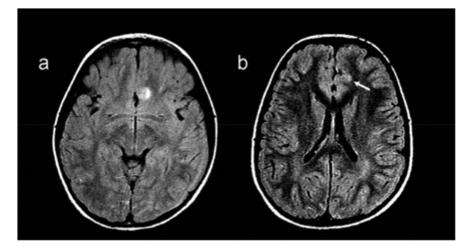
MRI at disease onset. Small areas of high-signal intensity in the left frontal lobe basal (a) and paramedian (b) regions (white arrow) (axial FLAIR).
